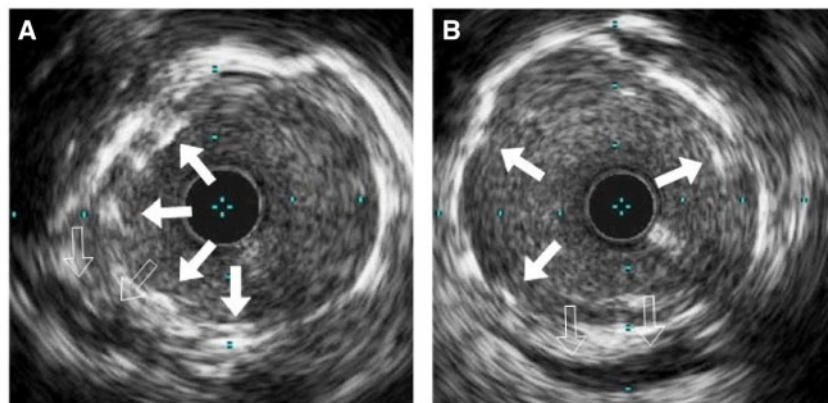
Final intravascular ultrasound registration of distal (A) and proximal (B) left main with a good expansion of the stent (full arrows) healing the huge dissection (empty arrows).
